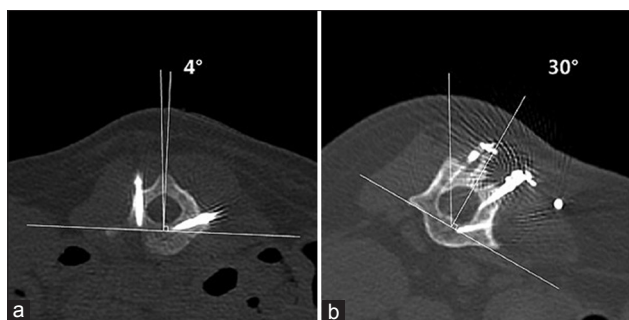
Computed tomography images of initial axial rotation (a) and final axial rotation (b) after surgery.
